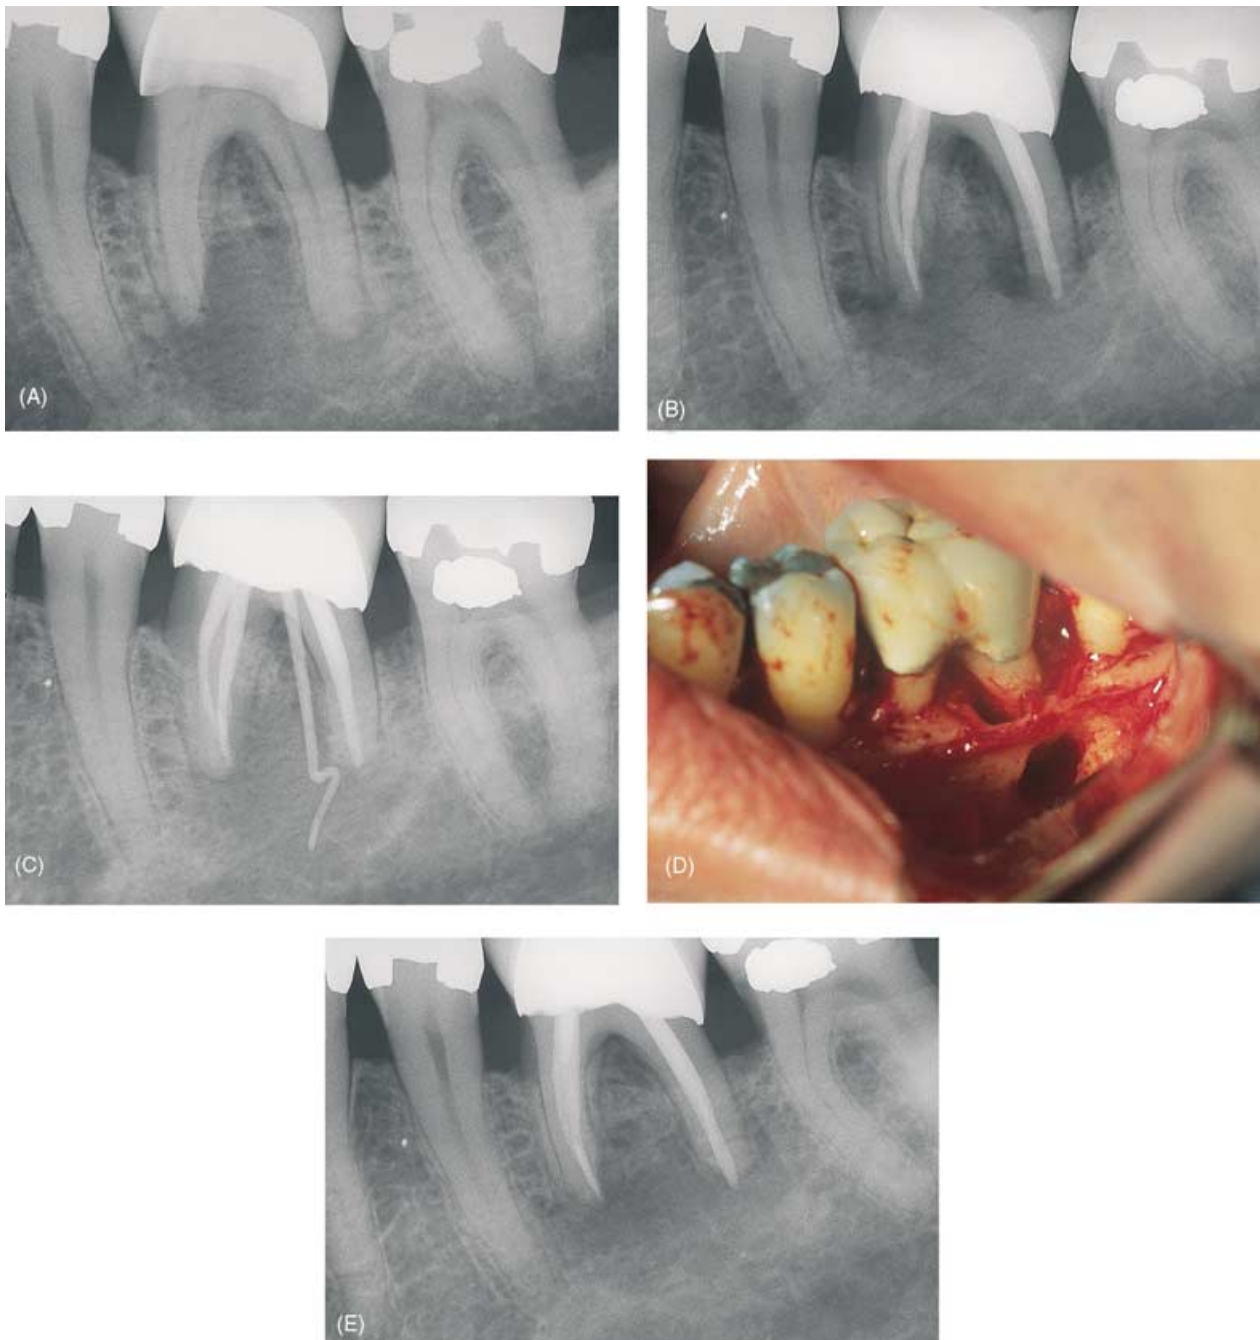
True combined endodontic-periodontal diseases in a mandibular first molar. (A) Preoperative radiograph showing periradicular radiolucencies. Pulp sensitivity tests were negative. (B) Immediate postoperative radiograph of nonsurgical endodontic treatment. (C)
